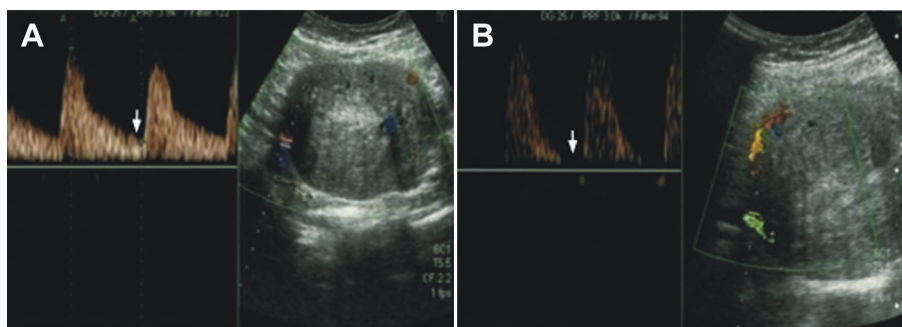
Comparison of the change in spectral Doppler of the blood flow in the myoma (A) before and (B) after misoprostol administration.
